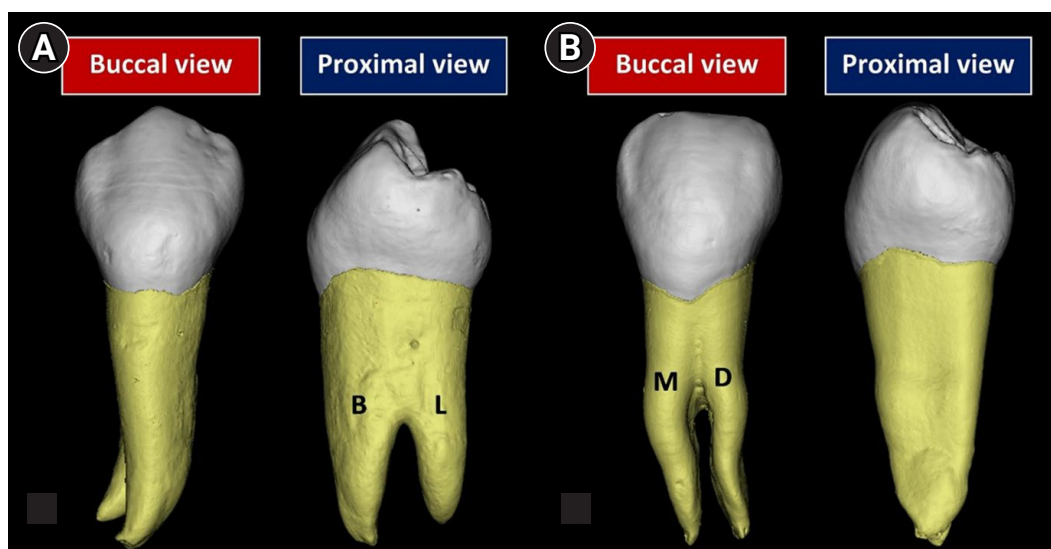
Micro-computed tomography reconstructed images of double-rooted mandibular premolars with (A) buccal and lingual roots and (B) mesial and distal roots. B, buccal; L, lingual; M, mesial; D, distal. Reproduced from Ahmed *et al.* [10], according to the Creative Commons License.
